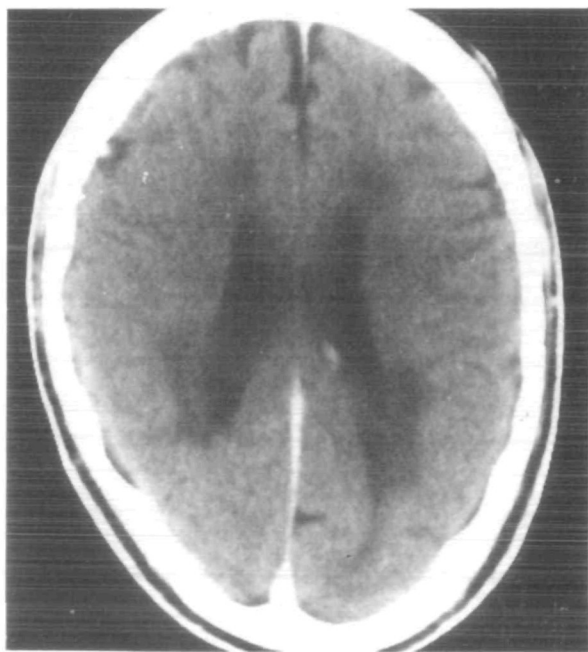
Contrast-enhanced head CT scan from *Case 11-6*. Note periventricular hypodensity with accentuation in the region of the frontal and occipital horns.
